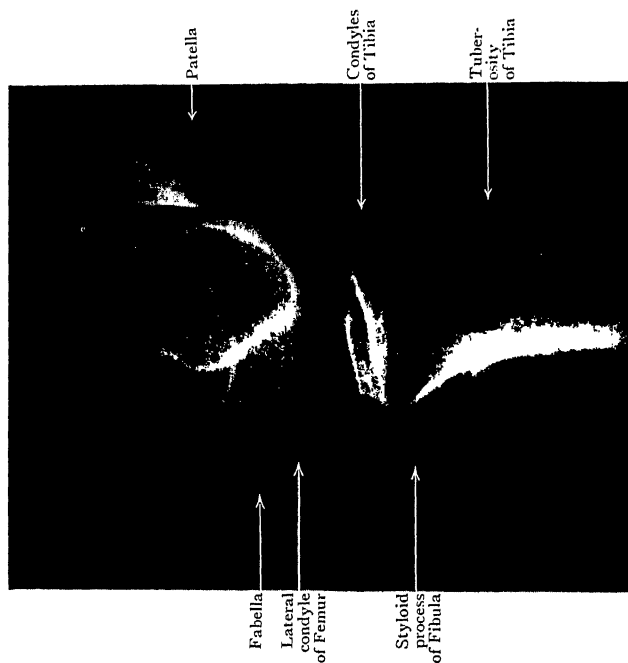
Lateral Radiograph of same Knee as in Fig. 17 t, in extension. Note the areas of contact of the Femur with the Patella and Tibia; also the sesamoid bone (Fabella) in the lateral head of the gastrocnemius muscle.
